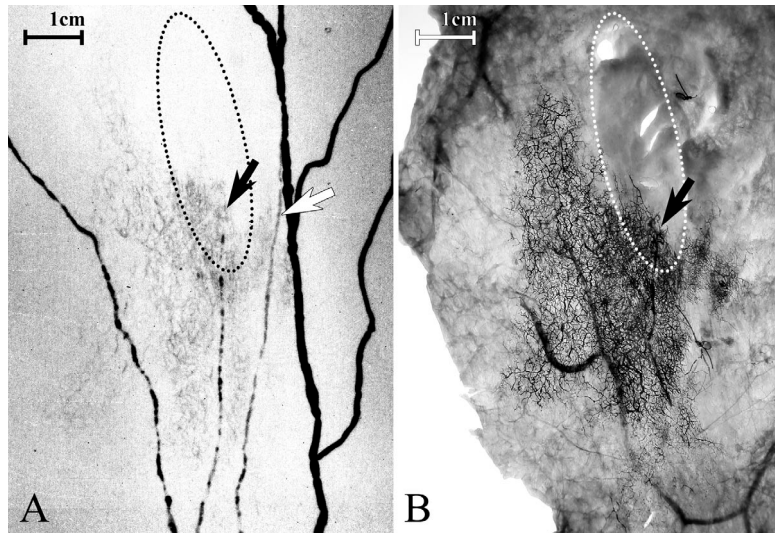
(A) Radiographic image including skin, subcutaneous tissue and deep fascia of the orange colored skin region. Dotted line outlines the position of the skin graft. The dermal lymph vessels were seen emphasizing a blocked lymph collecting vessel (black arrow) and an adjacent vessel (white arrow). (B) Transilluminated image of the skin of the same region depicts a dermal lymphatic network filled with lead oxide mixture.
